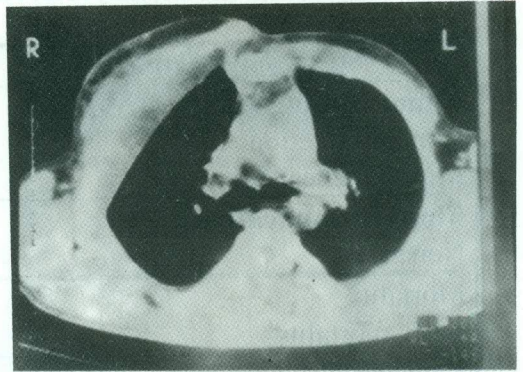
Postoperative CT of the same patient after reconstructive thoracoplasty using bone cement.
